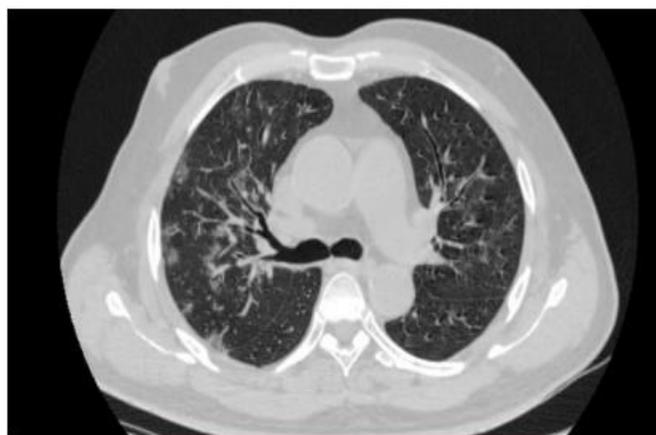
Axial HRCT Thorax lung window in vaccinated patient showing multiple peripherally predominant patchy areas of ground glass opacities in bilateral lung parenchyma, predominantly on right.
